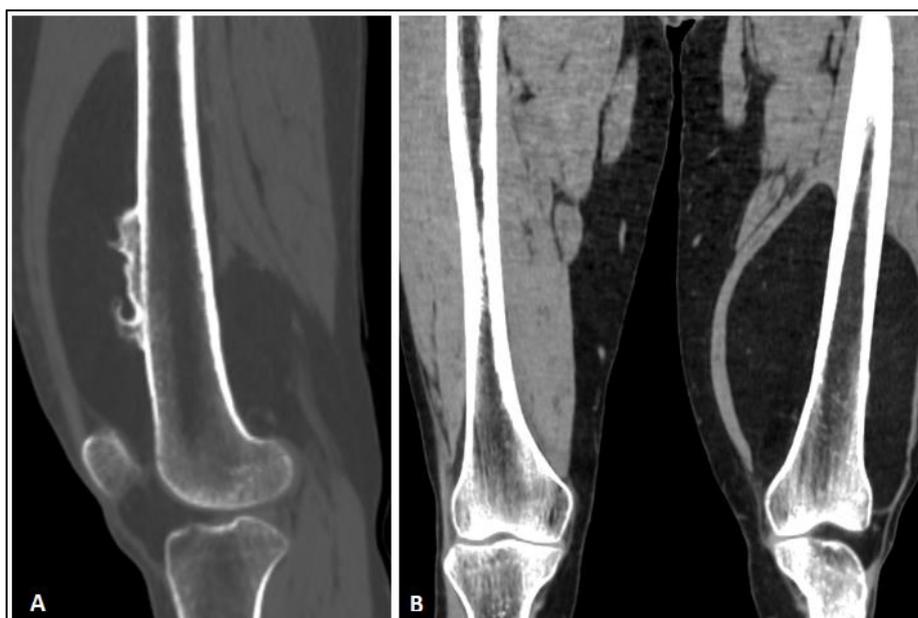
Sagittal (A) and coronal CT (B) showing an adipose juxtacortical mass of the left femur with osseous excrescences at the site of attachment
